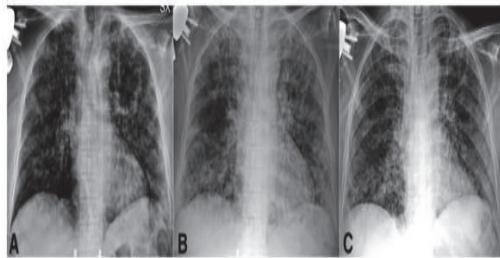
A) Chest X Ray showing pulmonary effusion. The distribution pattern is mainly peripheral. (B) Chest X-ray again 14 days later to identify the branching and effusion of fluid(C) Chest X-ray taken as a radiological data identified after Day 25 to find the change of the fluid accumulation in areas of the chest.
